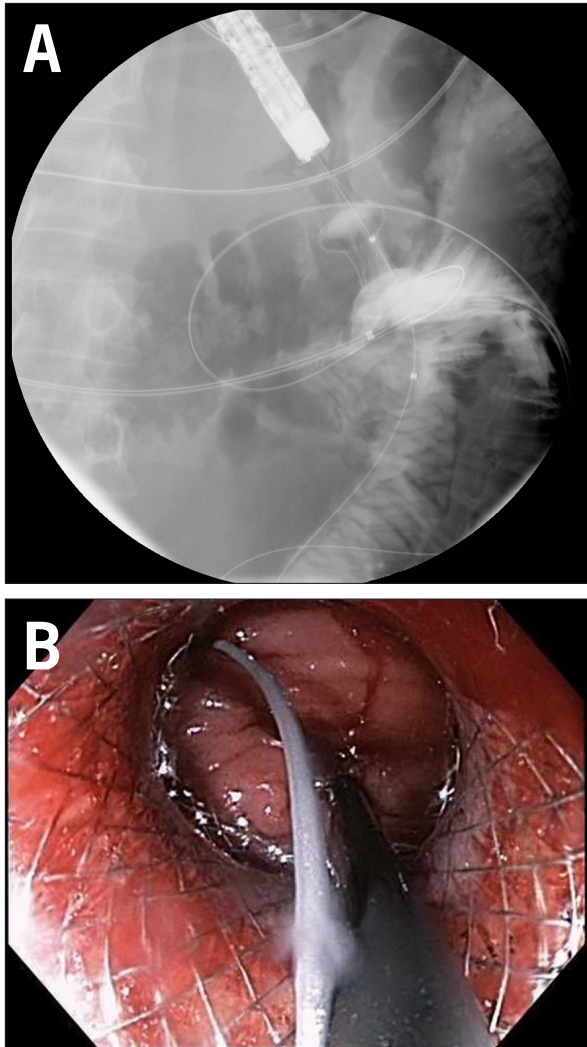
Fluoroscopic (A) and endoscopic (B) views of stent deployment in an endoscopic ultrasound–guided gastrojejunostomy.
